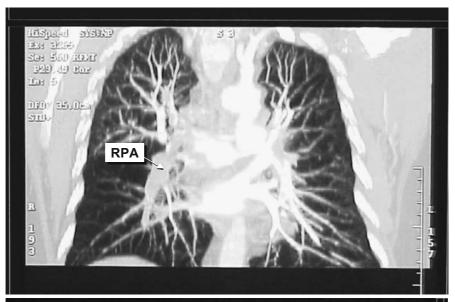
Patient case: 62-year-old woman with a history of frequent long-haul air travel and deep venous thrombosis presenting with 4- to 5-day history of dyspnea on exertion and moderate hypoxemia (room air pO_2 55). a Two images from spiral computed tomography (CT) scan with coronal reconstruction obtained at an outside emergency room demonstrating massive saddle pulmonary embolism extending into both right (*RPA*) and left (*LPA*) pulmonary arteries. The patient was transported to operating room by helicopter without further testing. b Intraoperative photograph (*upper image*) taken from the patient's left side (the patient's head is toward the right) demonstrating the saddle embolus straddling the bifurcation of the main pulmonary artery (*MPA*). The right ventricular outflow tract (*RVOT*), ascending aorta (*Asc Ao*), aortic cannula (*Ao Cann*), and venous cannula (*Ven Cann*) are labeled.
